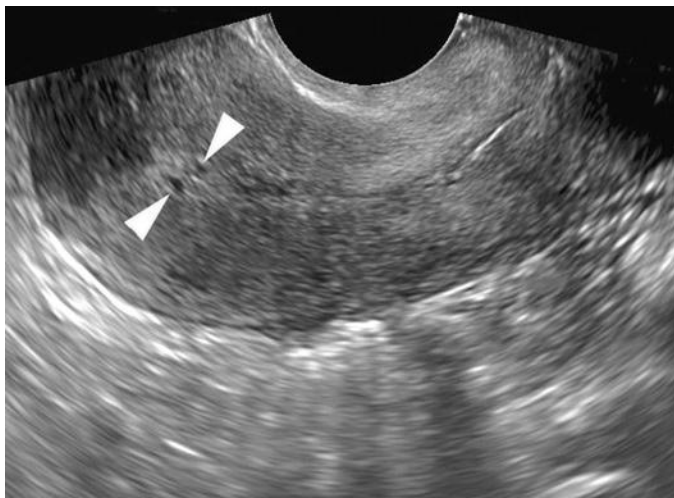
A 43-year-old woman with breast cancer and chemotherapy-induced ovarian failure now with abnormal uterine bleeding. Longitudinal transvaginal sonographic image of the uterus shows a thin endometrial stripe with small cysts (*arrowheads*) at the endometrial-myometrial junction, typically seen in cystic endometrial atrophy induced by tamoxifen. This sonographic appearance could mimic a small focal endometrial polyp with cysts.
